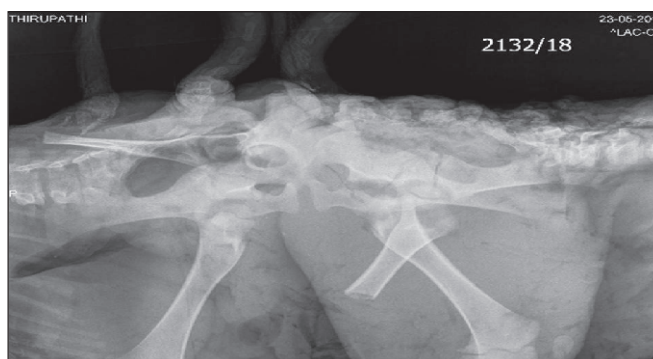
X-Ray showing fusion of pelvic joints confirming ischiopagus condition
